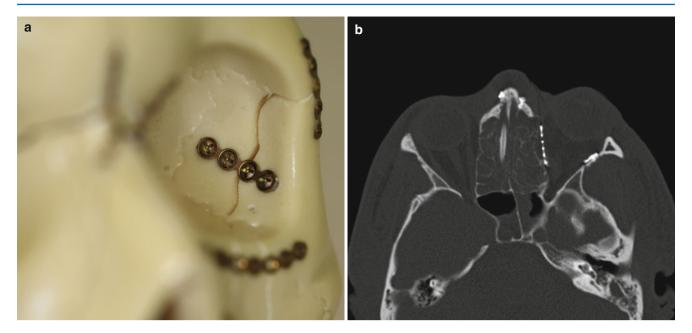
Plate position on model (a) and on CT (b). The lateral wall is satisfactorily aligned
